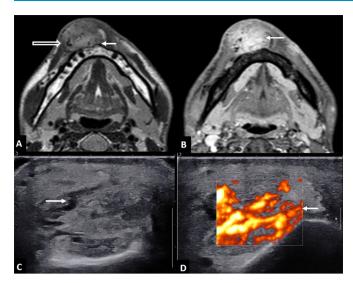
(A) MRI face-axial T2-weighted image shows a lobulated lesion in the subcutaneous plane of the chin, slightly to the right of the midline. Lesion is of intermediate signal intensity with few internal flow voids (arrow). The posterior margin is not well defined and is causing scalloping and mild thinning of the cortex of the underlying bone (open arrow). (B) Postcontrast T1-weighted image shows the moderate postcontrast enhancement (arrow). (C) Sagittal ultrasonography image reveals a heterogenous, solid lesion in the subcutaneous plane. The mass is predominantly echogenic with linear anechoic areas (arrow) which show colour flow on Doppler evaluation. (D) Power Doppler evaluation shows the markedly increased vascularity (arrow) within the lesion.
